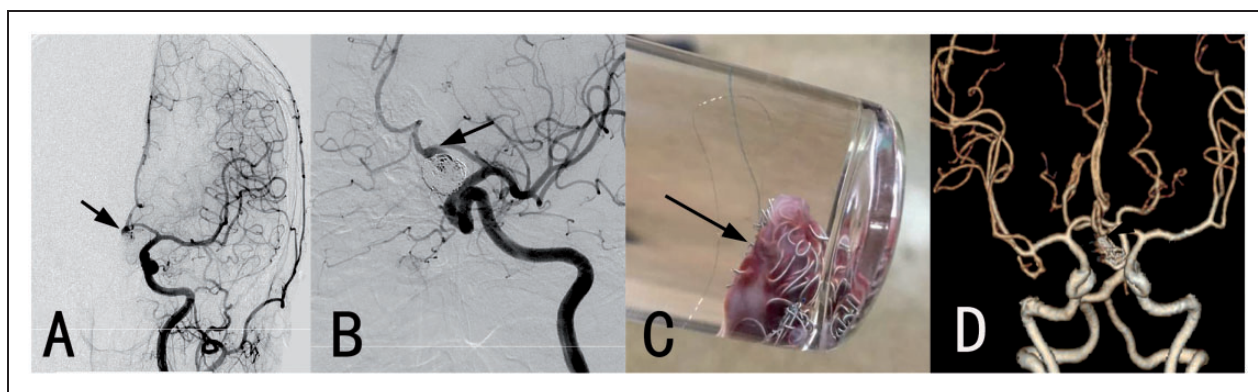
(a), (b) Six-month follow-up angiography showed the recurrence of the aneurysm sac (black arrow). Then we performed surgical clipping. (c) The excised aneurysm sac was preserved in a bottle of formalin. (d) Immediate postoperative CTA showed the complete obliteration of the aneurysm sac (black arrow). CTA: computed tomography angiography.
